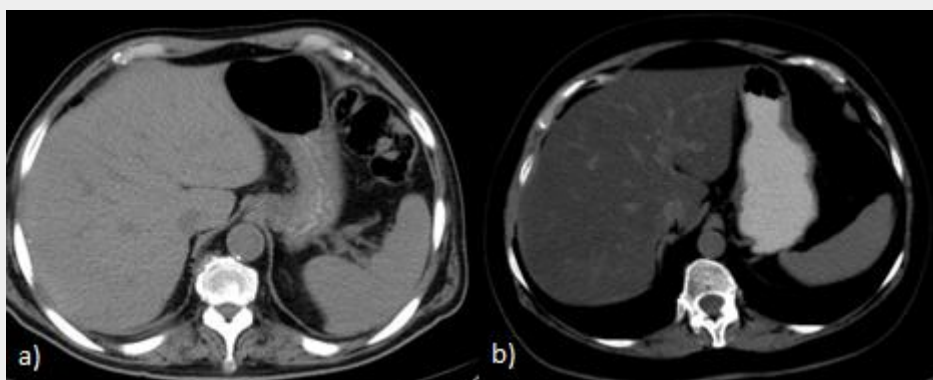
CT non-contrast axial images showing normal hepatic parenchyma density (a) and a severe case of diffuse fat infiltration with a reversed vascular pattern (b).
